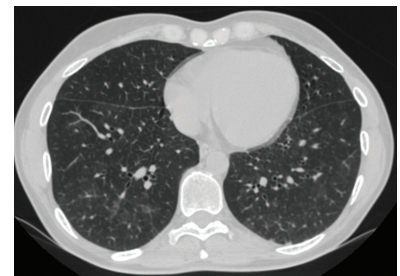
The synchronous HRCT depicts a normal lung without significant scars from the previous insult except a minimal ground glass opacity in the superior segment of the right lower lobe.
